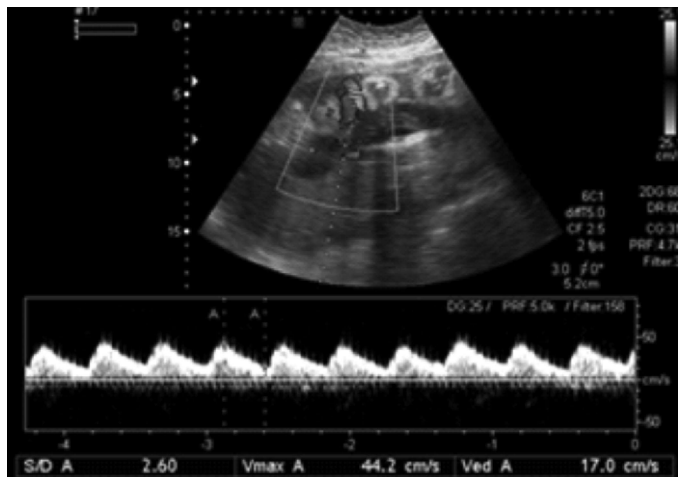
Systolic/Diastolic ratio of Umbilical Artery Doppler in IUGR Negative case
